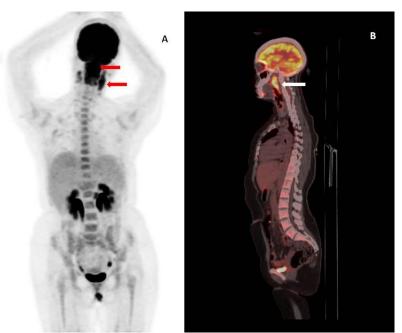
Initial 18-FDG PET scan (MIP on the left and sagittal slice on the right) showing foci of hypermetabolism in the tumor process of the cavum extending to the oropharynx associated with bilateral cervical hypermetabolism suggesting lymph node involvement
